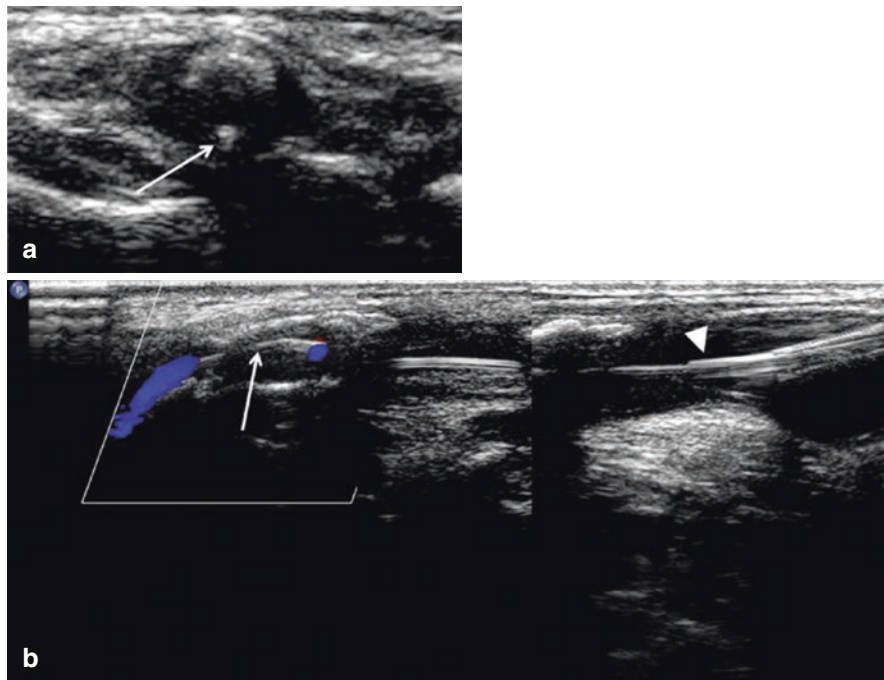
Ultrasound check of the catheter (white arrowhead) and the microwire tip (white arrow) in axial (a) and longitudinal (b) images. (Reproduced from Nico et al. [26]. With permission from BMJ Publishing Group Ltd.)
